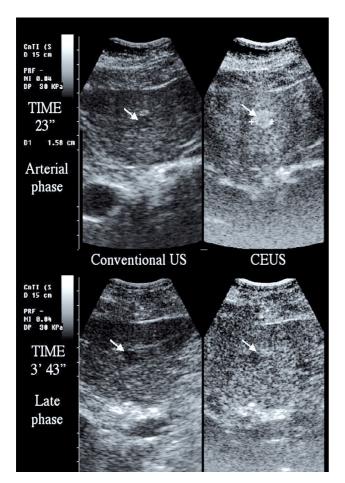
A small nodule (16 mm in diameter, white arrow) is detected by conventional ultrasonography (US) in a cirrhotic subject during surveillance. Real time contrast enhanced ultrasonography (CEUS) is immediately performed, showing a hypervascular pattern in the arterial phase (upper panel; left frame shows conventional sonography appearance, whereas the right panel depicts the CEUS pattern in the same moment. The nodule appears hyperchoic at CEUS in the arterial phase, 23 seconds from contrast injection, as indicated by the time on the left. A contrast wash out is evident in the late venous phase (lower panel). Such a pattern is suggestive for hepatocellular carcinoma.
